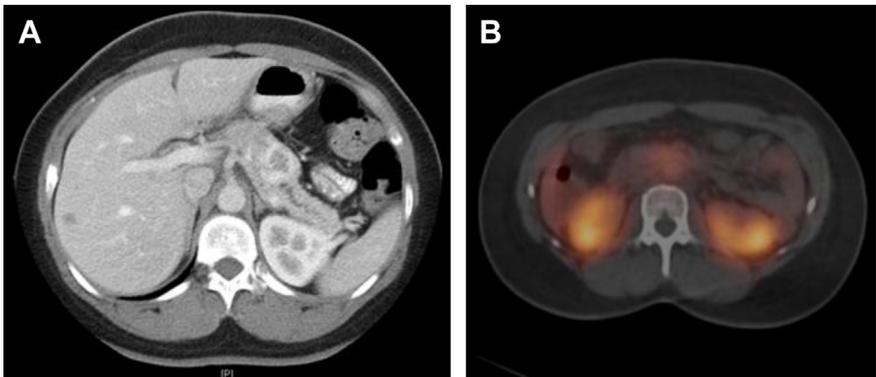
Representative image (A) from contrast-enhanced CT for a 36-year-old woman presenting with vague abdominal pain demonstrating characteristic hyperenhancement on arterial phase typical of PNETs. The hypointense lesion in the right lobe of the liver was not visualized on octreotide scan, evaluated by MRI, and found to be a cyst. The pancreatic mass was managed by laparoscopic distal pancreatectomy with splenectomy. The patient is now 2 years post resection with no evidence of recurrence. Representative image (B) from octreotide scan for the same patient preoperatively. The image demonstrates mild octreotide binding typical of an NF-PNET.
